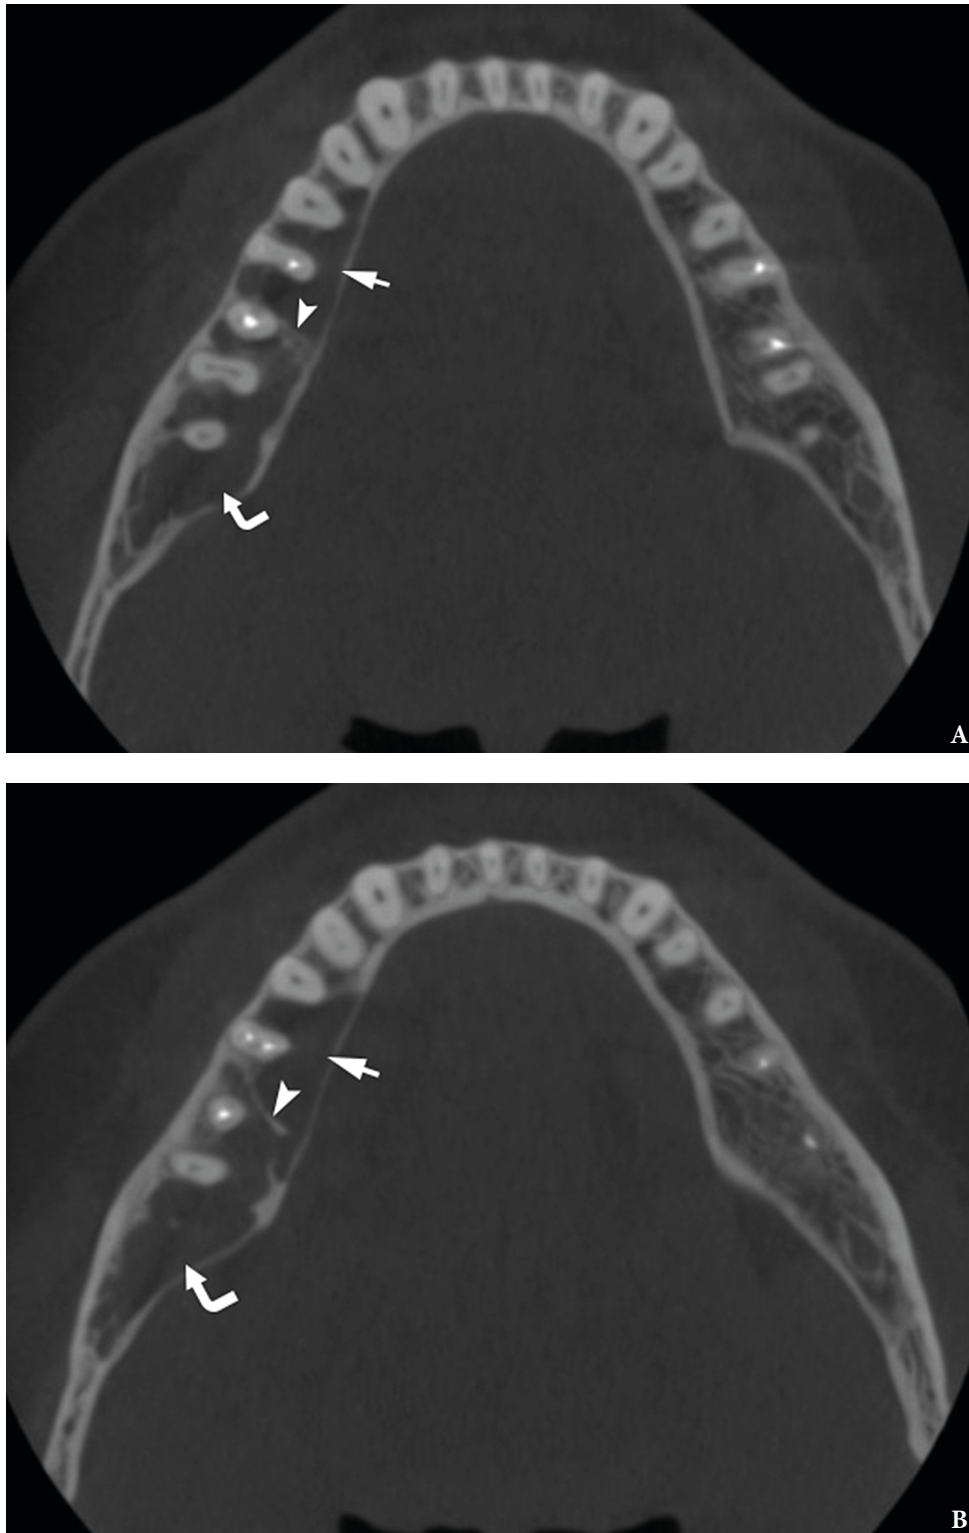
Cone beam computed tomography (CBCT). Axial scan at the level of upper parts (A) and middle parts (B) of roots of the teeth #45–47. Anterior camera of simple bone cyst is indicated by *straight arrow*, posterior camera – by *curved arrow*, intracystic septa – by *arrowhead*. (Fig 2 continued on next page.)
